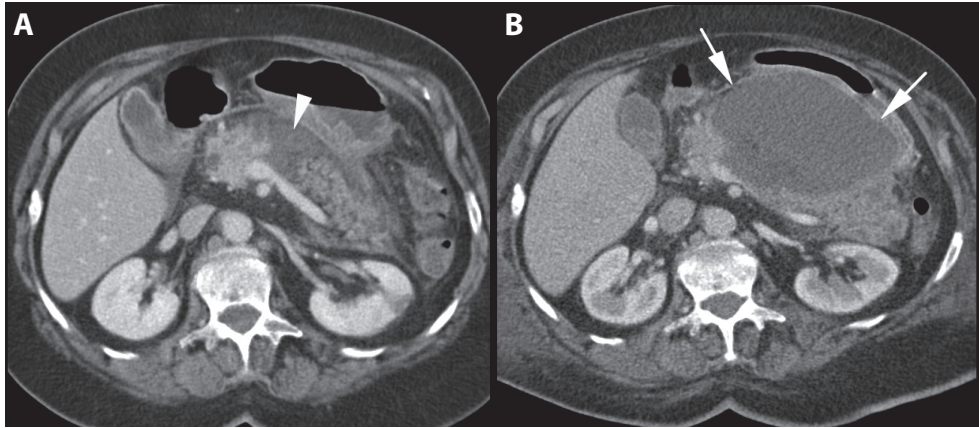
Central gland necrosis – pattern 2. (A) CT depicts an area of non-enhancement at the body of the pancreas (arrowhead) representing <30% extent of necrosis with viable upstream pancreatic tissue. (B) Follow-up CT at day 17 shows a significant enlargement of the associated necrotic collection (arrows) abutting the stomach, likely related to a disrupted pancreatic duct.
